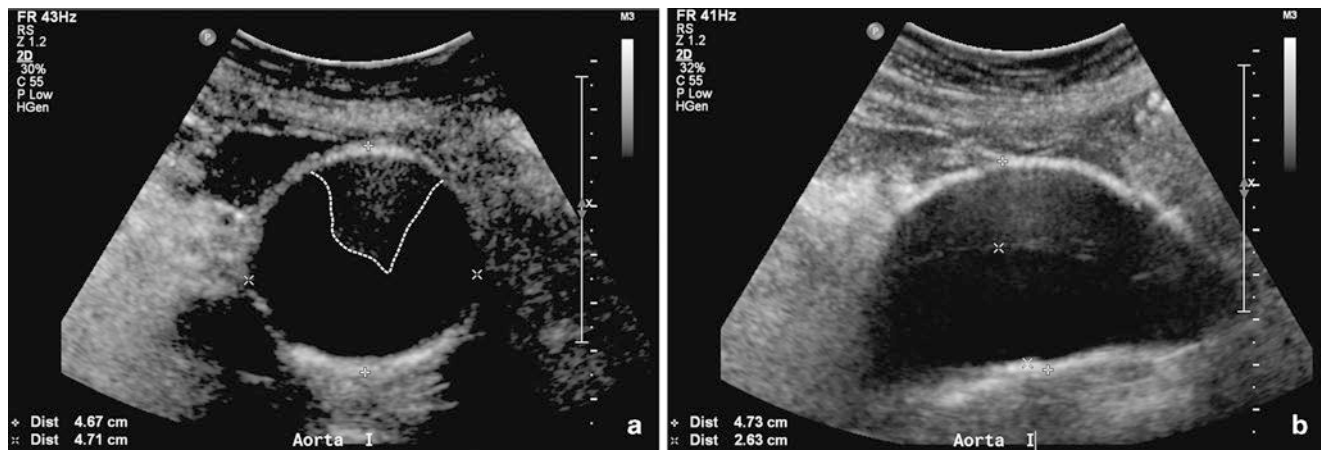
Ultrasound of native aorta showing abdominal aortic aneurysm, (a) transverse view – notice intraluminal thrombus (*dotted line*), (b) sagittal view
